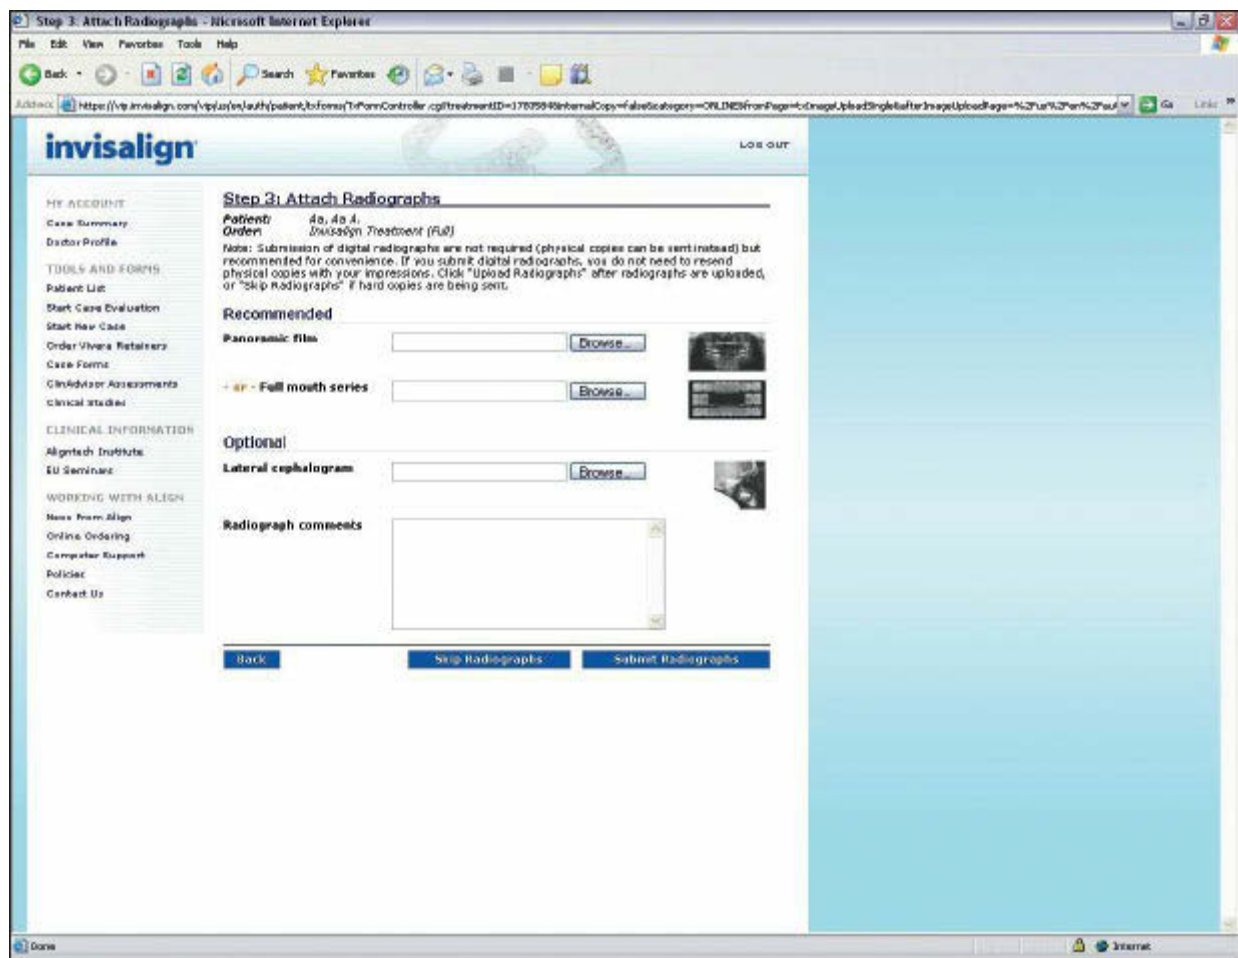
Uploading of radiographic images via VIP.
